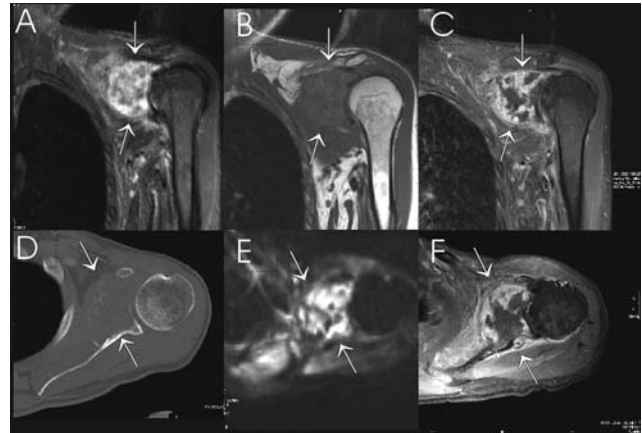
MR image findings of the left shoulder in a 48-year-old man suffering from epithelioid angiosarcoma of the scapula. Coronal views are displayed in the upper row, axial views are shown in the lower row. A: T2-weighted inversion recovery sequence. B: T1-weighted spin-echo sequence; C, F: fat-saturated T1 gradient echo sequence; E: diffusion-weighted sequence. A large tumour destruction of the glenoid and the adjacent scapula is seen (arrows). The lesion exhibits a high inhomogeneous signal in diffusion-weighted and T2-weighted sequences (A, E) and a rather homogeneously low signal on T1-weighted imaging (B). In contrast-enhanced images (C, F), a strong contrast-enhancement is seen, indicating the vascular origin of the tumour. However, the signal loss, particularly in the centre of the lesion indicates distinctive necrosis.
